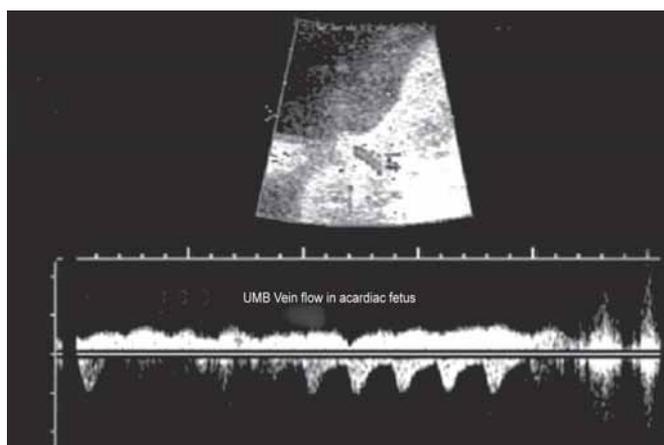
Doppler showing reversed blood flow in umbilical vein of acardiac fetus
